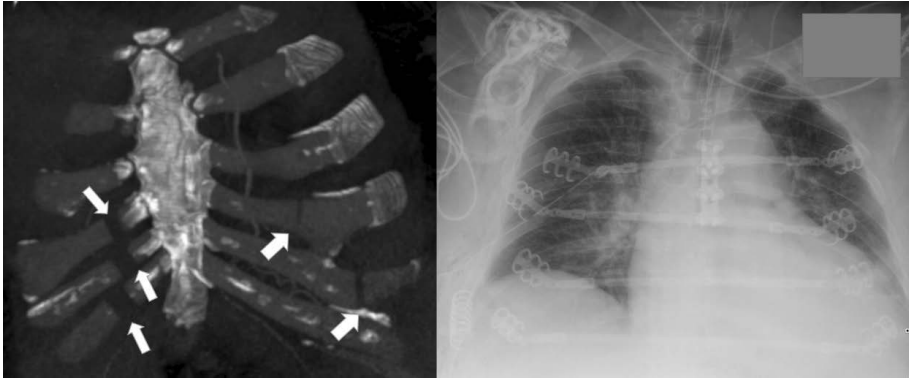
64-year-old male, motor vehicle accident. Flail chest, failure to wean from mechanical ventilation. CT MIP (20 mm) image on the left. Multiple consecutive CCFXs bilaterally (arrows) that result in anterior chest wall instability. The fractures were fixated with struts crossing the sternum. Postoperative chest x-ray on the right.
